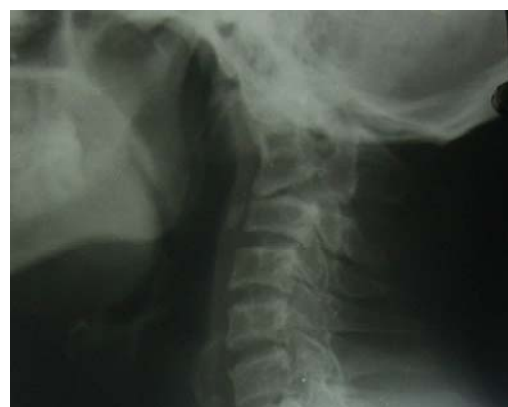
Plain X-ray of the cervical spine after a six-week follow-up showing spontaneous resorption of the graft
